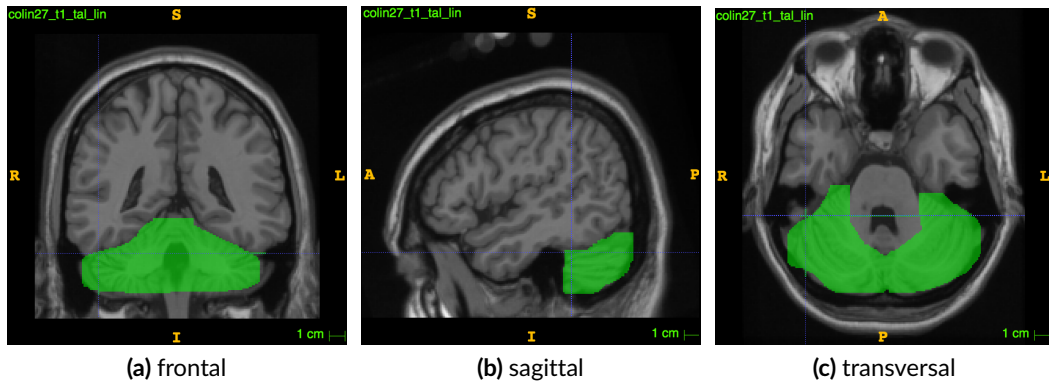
Use of *ITK-SNAP* [209, 210] to extract the cerebellum in MR images of the “Colin 27” data set [195].
